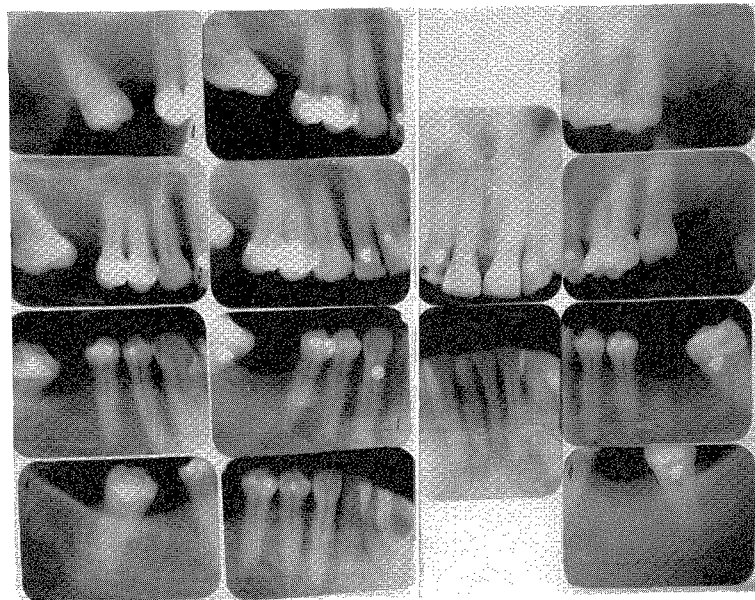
1929 roentgenograms of the patient at the age of 50.
